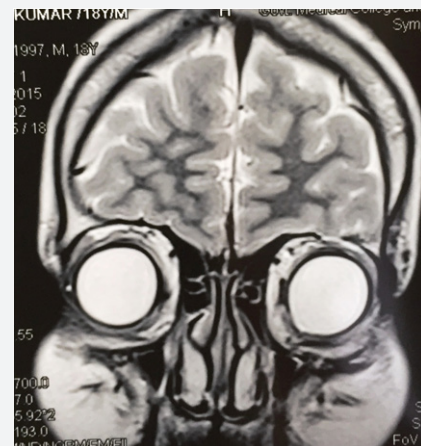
MRI: showing Aplasia of olfactory bulbs.
